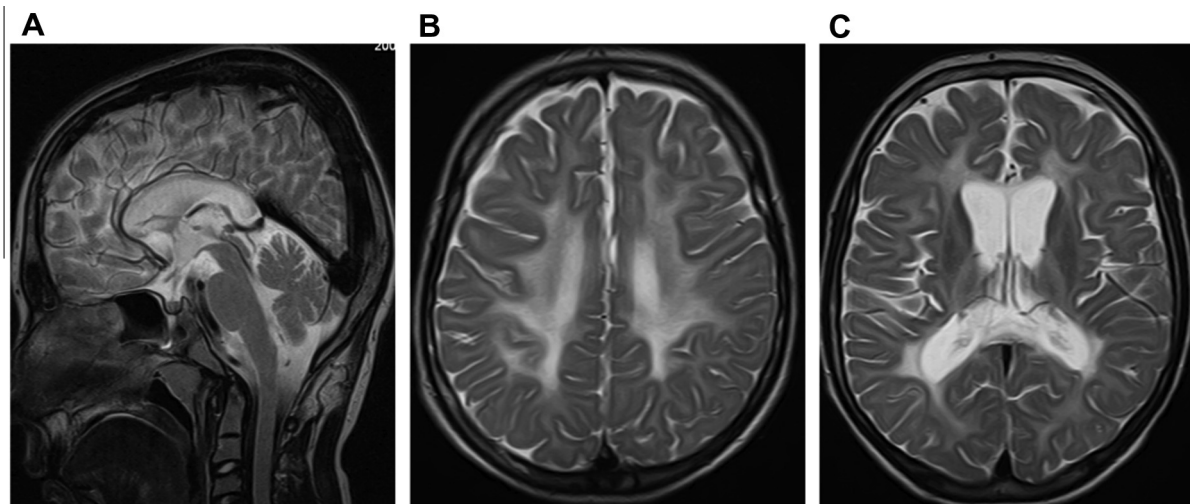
Sagittal and axial T2-weighted brain MRI images of the proband at 14 years of age. (A) Note: the thin and unmyelinated corpus callosum. (B) Diffuse white matter hyperintensity of the centrum semiovale is seen. Lack of myelination of the corticospinal tracts. (C) The image at the level of basal ganglia. Abnormal, high signal of the internal and external capsules. The periventricular white matter is also involved. Enlarged lateral ventricles are seen.
